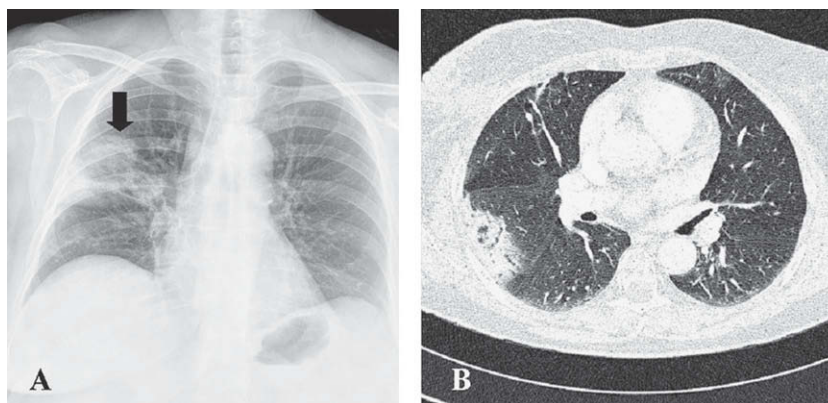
A. plain chest radiography (posteroanterior projection), showing a solitary pulmonary nodule and an area of consolidation in the upper right lobe (arrow). B. Axial section of a chest CT scan of the lung, showing peripheral condensation, with small areas of cavitation surrounded by ground-glass opacities.
